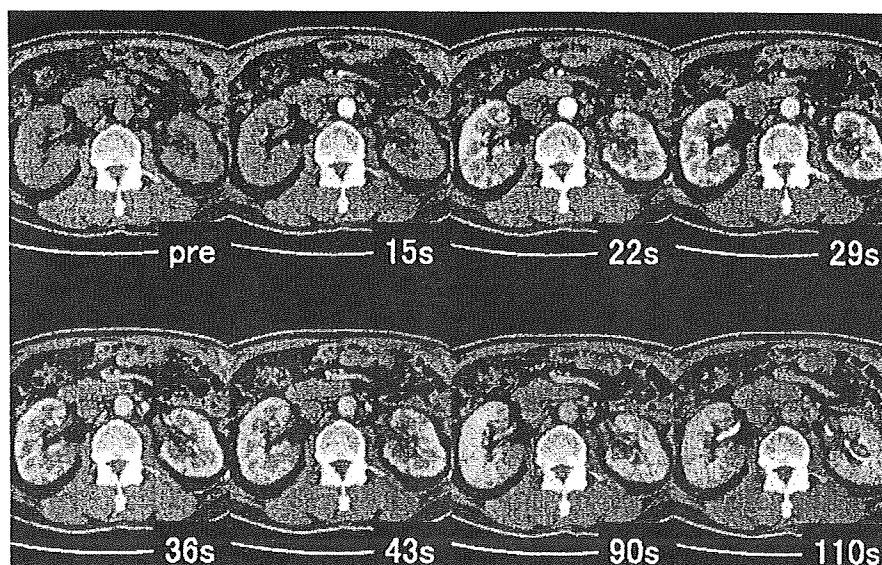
Renal lesions in a 67-year-old man (same case as in Fig. 1). Multiphase dynamic contrast-enhanced CT shows multiple poorly enhanced lesions in both kidneys, and sequential changes in the lesions over time.
